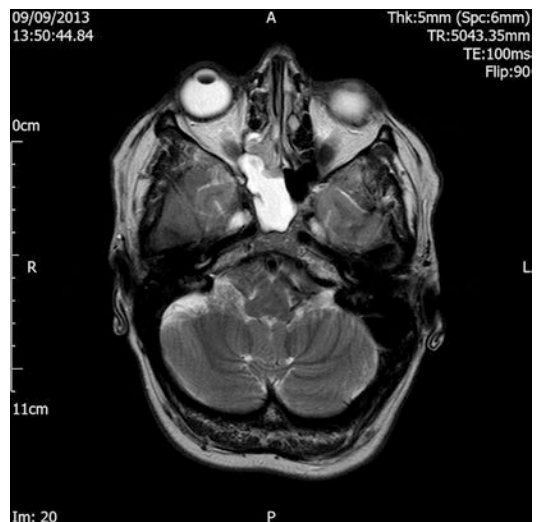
T2-weighted axial MRI of the paranasal sinuses with a hyperintense lesion in the right sphenoid sinus extending to the right posterior ethmoids (mucocele) and abutting a heterogenous lesion in the right posterior ethmoid sinuses (suspected tumour)
